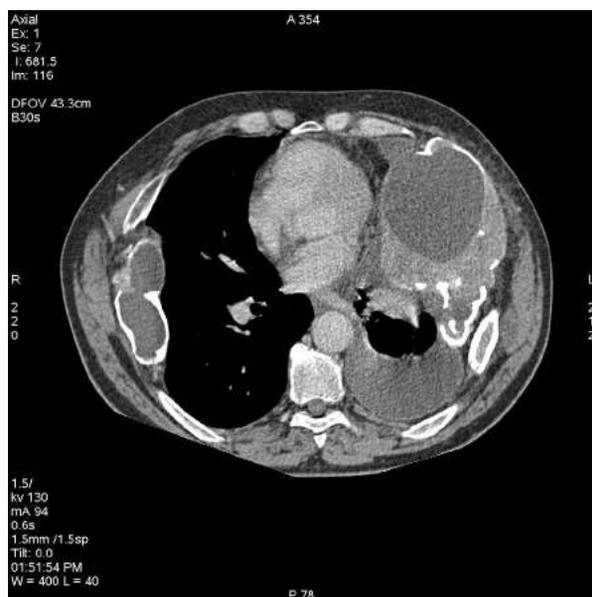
Computed tomography shows multiple massive expansile osteolytic rib lesions with left sided pleural effusion
